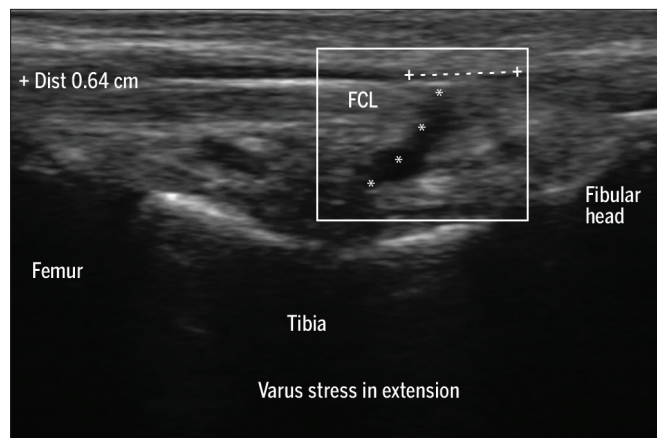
Long-axis dynamic ultrasound image of the fibular (lateral) collateral ligament (FCL), with varus stress, in 0° of flexion. Expansion of the hypoechoic area up to 0.64 cm, extending to the surface with diffuse hypoechoic, suggests laxity and disruption of the ligament fibers.
